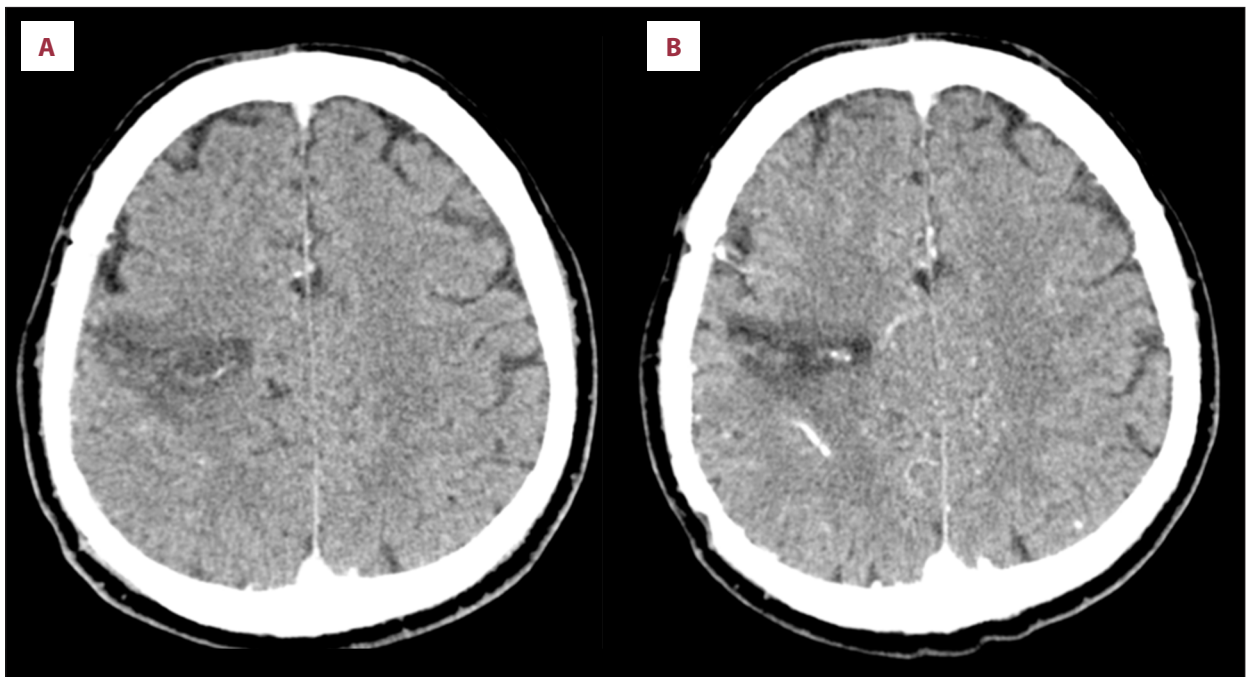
Control non-contrasted computed tomography scans. These scans were performed on the third postoperative day (A–C), showing marked reduction of the hemorrhage and perilesional edema.
